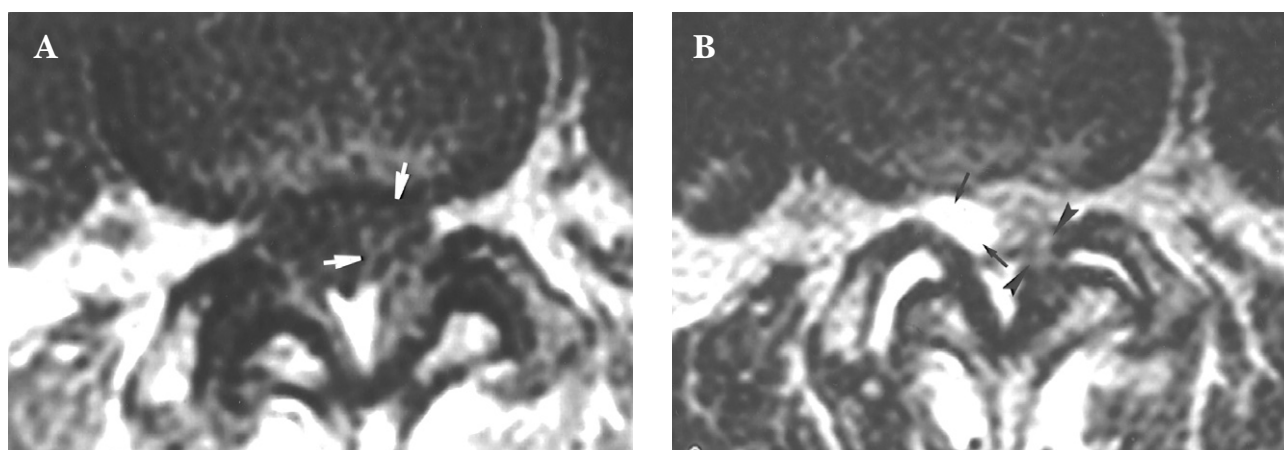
(A) A hypointense mass on axial T1-weighted image (white arrows). (B) A centrally hyperintense and marginally hypointense mass on T2-weighted image. There is disruption of the left ligamentum flavum (arrowheads) and the thecal sac is displaced to the contralateral side (arrows).
